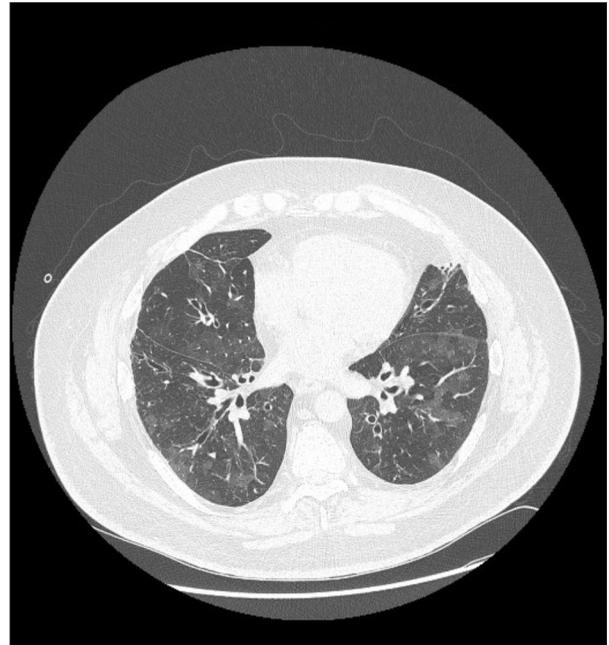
Selected computed tomography scan.
